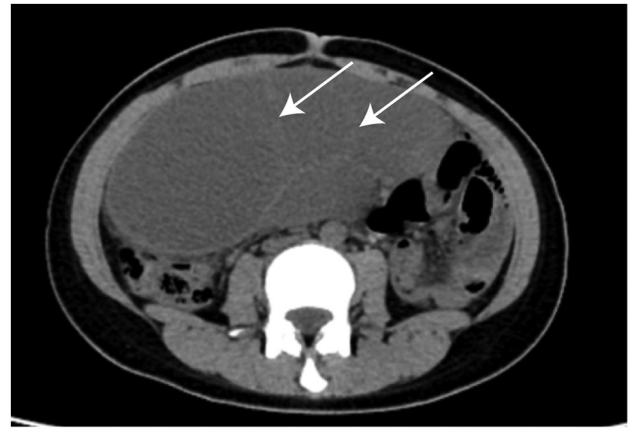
CT scan demonstrating a giant multilocular cystic mass occupying the entire abdominopelvic cavity. Multiple internal septations are visible (arrows), with well-defined margins and no solid enhancing components. The lesion displaces adjacent organs, including the bowel loops and adnexal structures.
